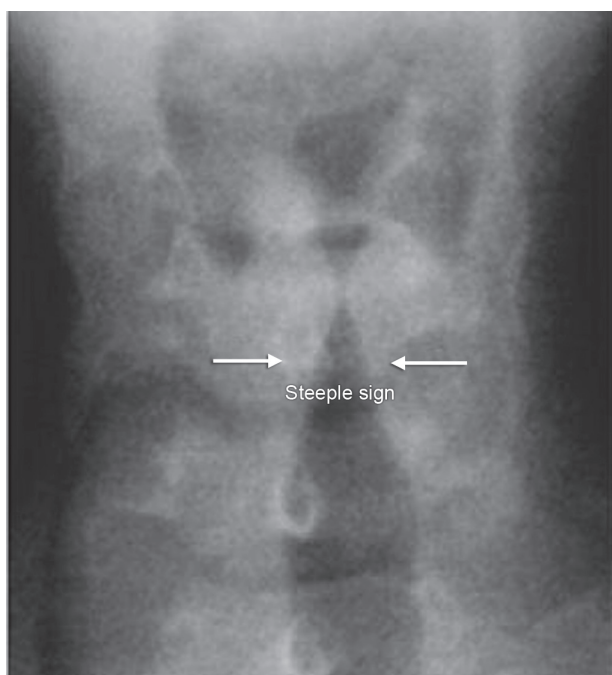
Anteroposterior radiograph of the upper airway of a patient with croup. The subglottic tracheal narrowing produces an inverted V appearance known as “steeple sign” (arrows)
